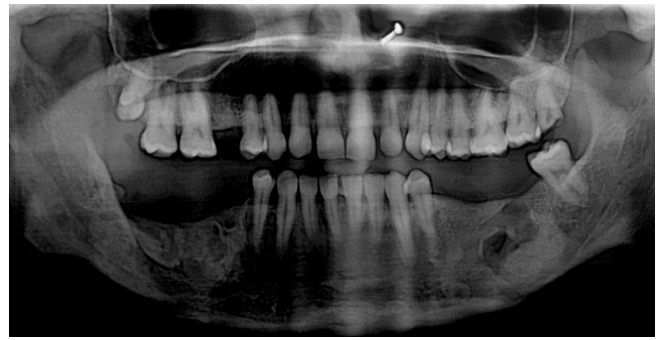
One-year follow-up orthopantomogram (OPG) showing healing of both the brown tumours with sclerosis.
